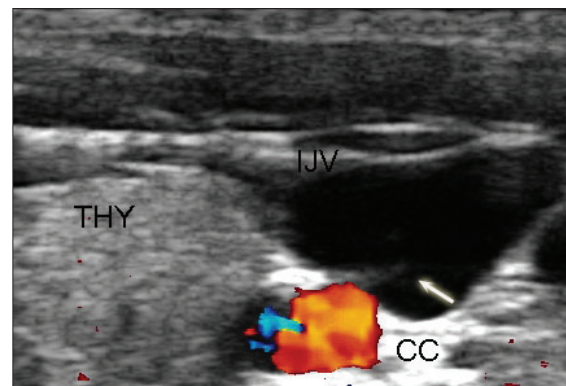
Septum and flow block in an internal jugular vein on echo-color Doppler
